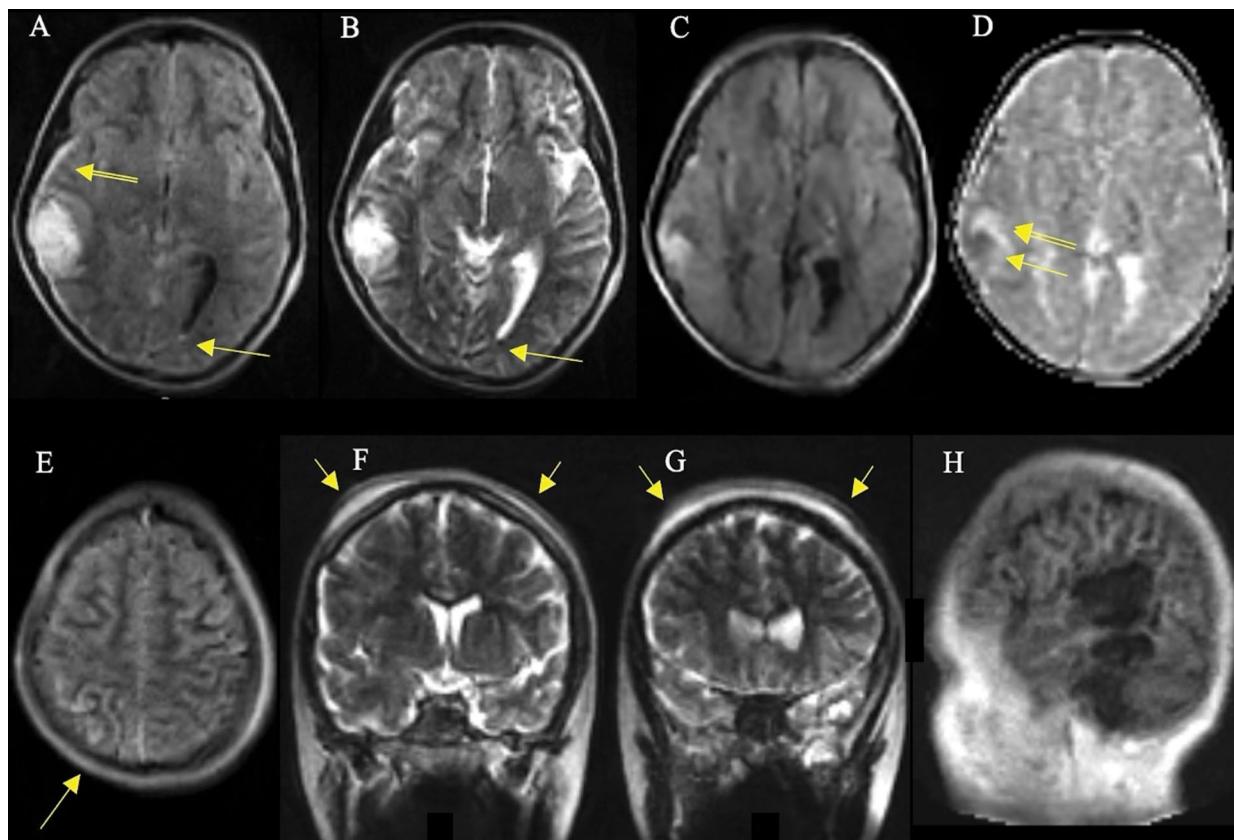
Axial flair image (A) performed at 14:19 pm, approximately 6 hours following admission CT, reveals better delineation of the right temporal lobe contusion with compression of right temporal (not shown) and occipital horns. Thin right-sided subdural hemorrhage (double arrows, B) is readily apparent on flair image. A tiny focus of dependent intraventricular hemorrhage is seen on both flair (bright signal, arrow A) and T2-weighted (dark signal, arrow B) images are now evident. A small area of intralesional hyperintensity on the diffusion-weighted image (C) matches the area of diffusion restriction (long arrow, D) on apparent diffusion coefficient (ADC) image (D) and corresponds to the small amount of hemorrhage on the earlier CT. Note hyperintense perilesional edema anterior to hemorrhage on ADC (double arrow D). Hyperintense sulci reflecting subarachnoid hemorrhage are also revealed on flair image (arrow D). Hyperintense scalp edema over frontal convexities is also appreciated on coronal T2-weighted images (small arrows E and F). Sagittal T1-weighted image (H) shows hypointense contusion extending from superior to inferior temporal gyri, also noted on coronal T2-weighted images (not shown). Follow-up imaging (not shown) at 2 months showed significant resolution.
